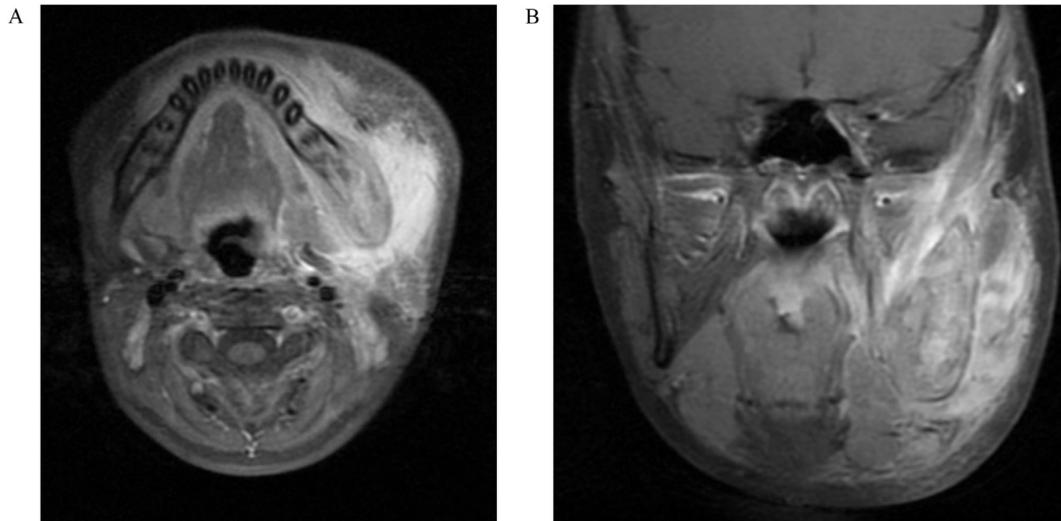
The gadolinium-enhanced fat-suppressed T1-weighted magnetic resonance imaging in the face (A: axial image, B: coronal image).
